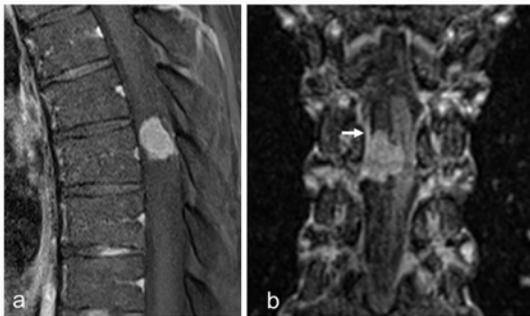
The tumor marked and homogenous enhancement is observed on contrast-enhanced sagittal T1-weighted images. On coronal view dural tail sign is indicated (arrow).
